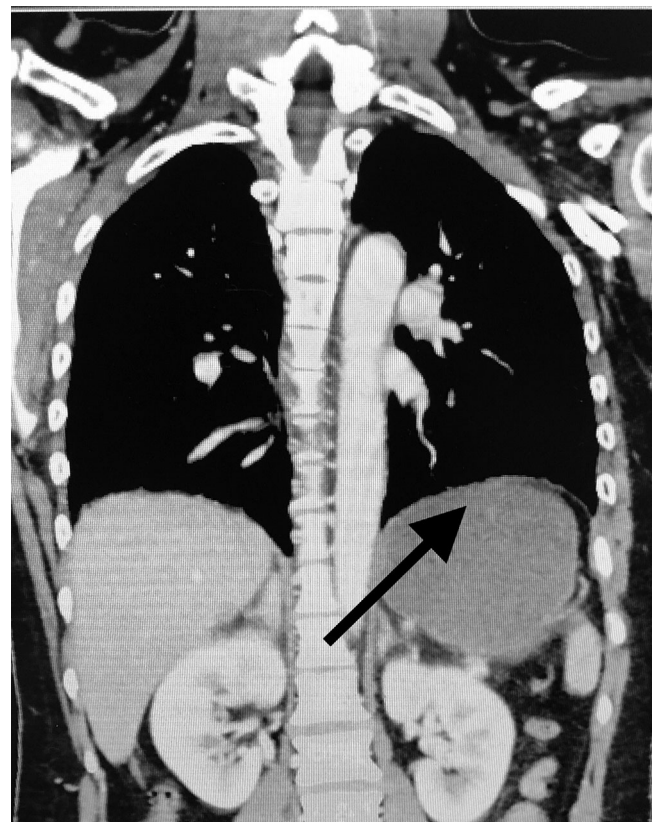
A coronal slice of a contrasted computed tomography on the day of the motor vehicle collision without evidence of diaphragmatic injury (black arrow)
